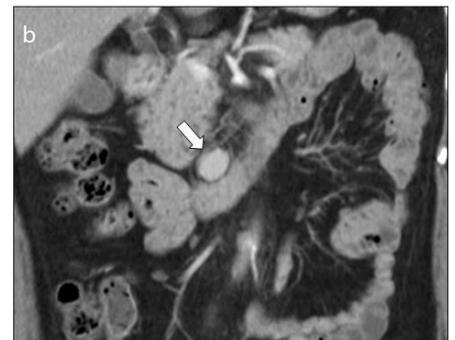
a, b. CT image in a 49-year-old woman with Castleman's disease. Portal phase axial (*a*) and coronal (*b*) CT images show a 1.9 cm ovoid homogeneous enhancing lesion (*arrow*) in precaval space. It shows preservation of the fat plane between the mass and the duodenum, which is indicative of an extramural subepithelial mass. It was proven to be the Castleman's disease, hyaline vascular type, in biopsy.
